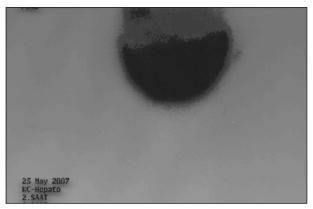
Control peritoneal scintigraphy after 1 month.
